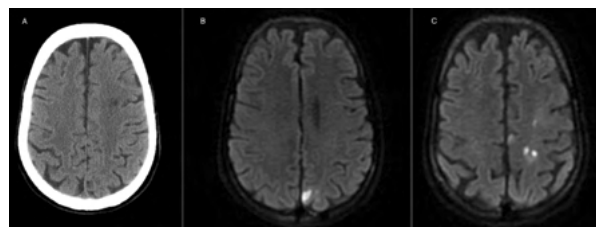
Case 1: A: CT Brain showing small hypodensity in left frontal and parietal lobes; B, C: MR Brain DWI sequence showing multiple embolic infarcts
